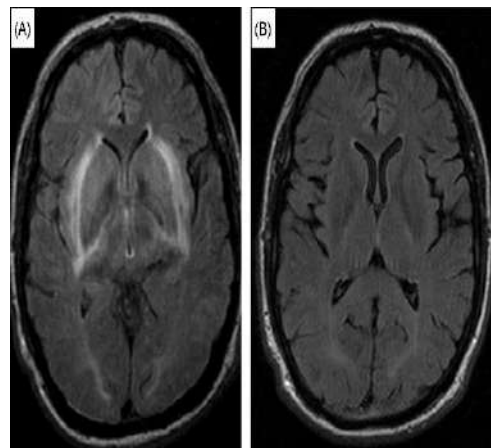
MRI Scan of the Brain [6]
